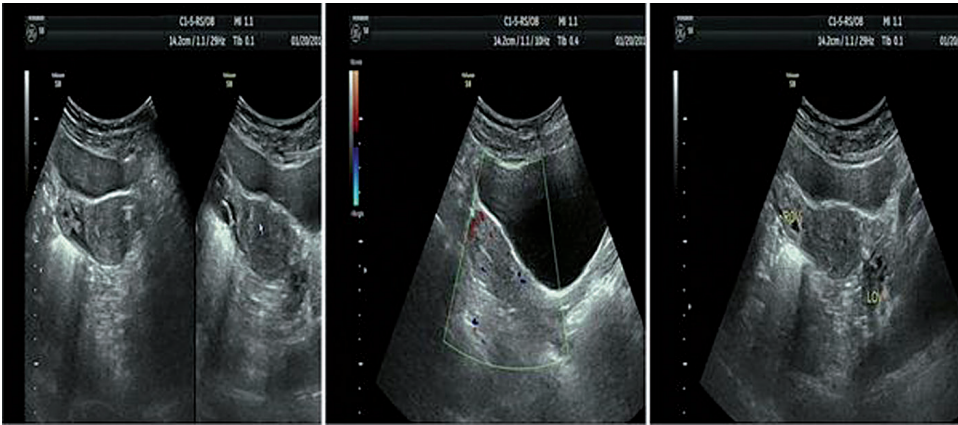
Color ultrasonography performed on January 20, 2014.
